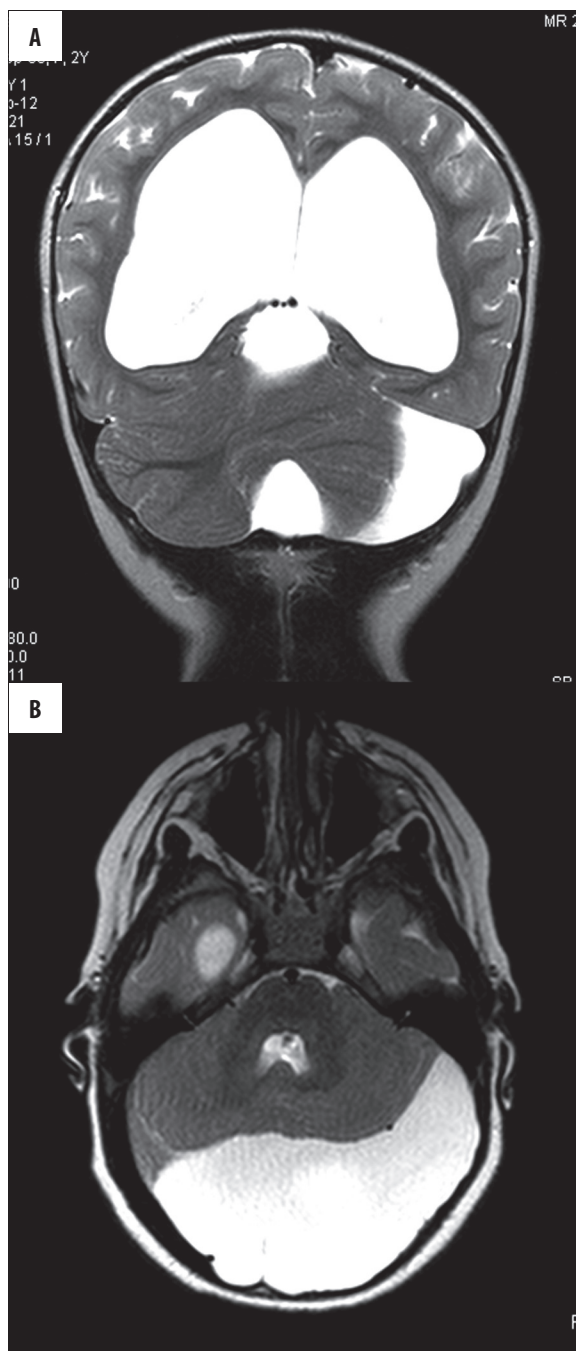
Case 7. Arachnoid cyst in the posteriori cranial fossa compressing the cerebellum. Cerebellar hypoplasia, especially of the left hemisphere. Partial RES. Hydrocephalus. FSE/T2-weighted images. (A) Coronal plane; (B) Axial plane.
